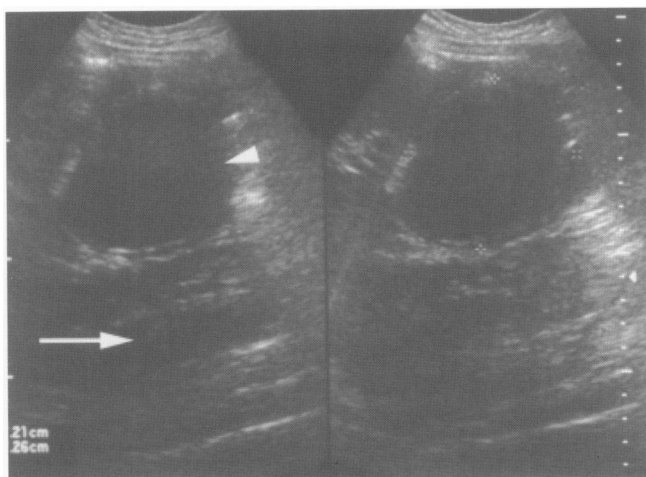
Ultrasound image showing the retroperitoneal lymphangioma (short white arrow). Note the lack of expected 'through transmission' normally expected from a serous cyst (long white arrow).
